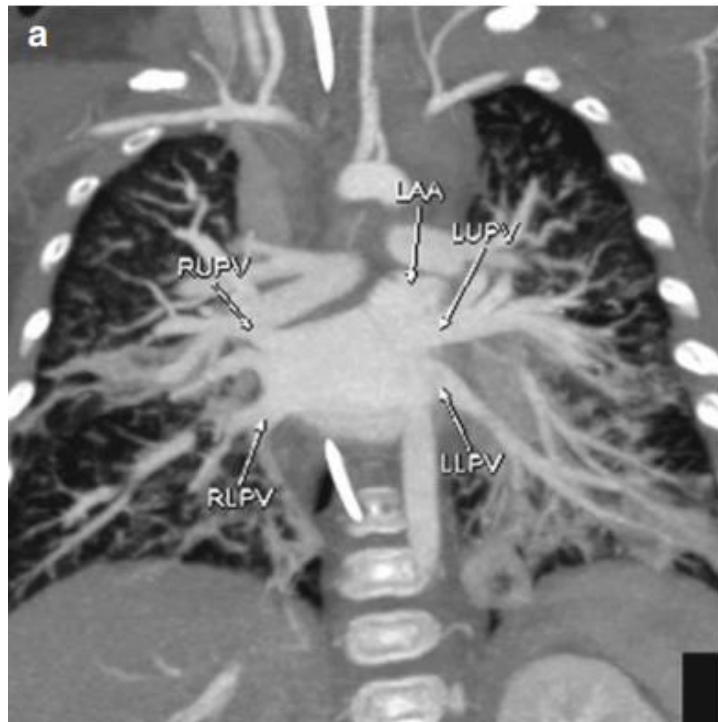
CT Coronal MIP view showing superior and inferior pulmonary veins of both sides connected to the LA (*Quoted from Richardson, 2013*).
